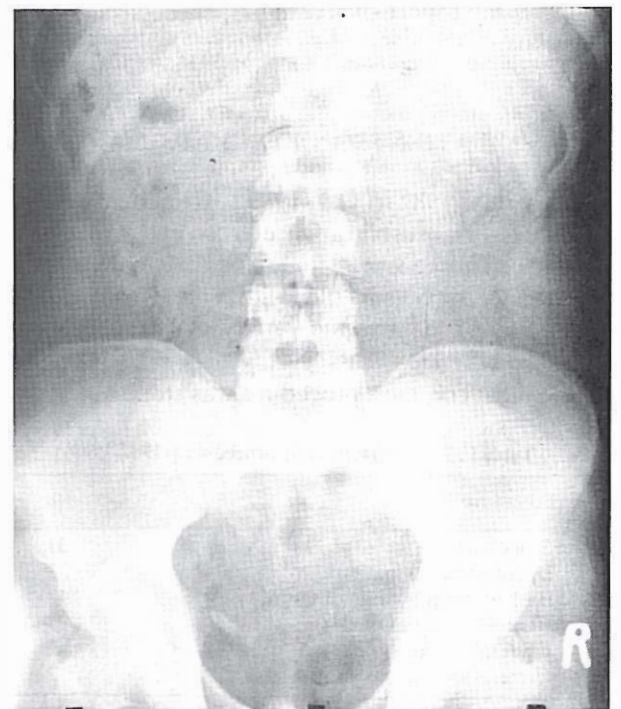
Plain film of one of the patients with ureteral stone (lower third).
